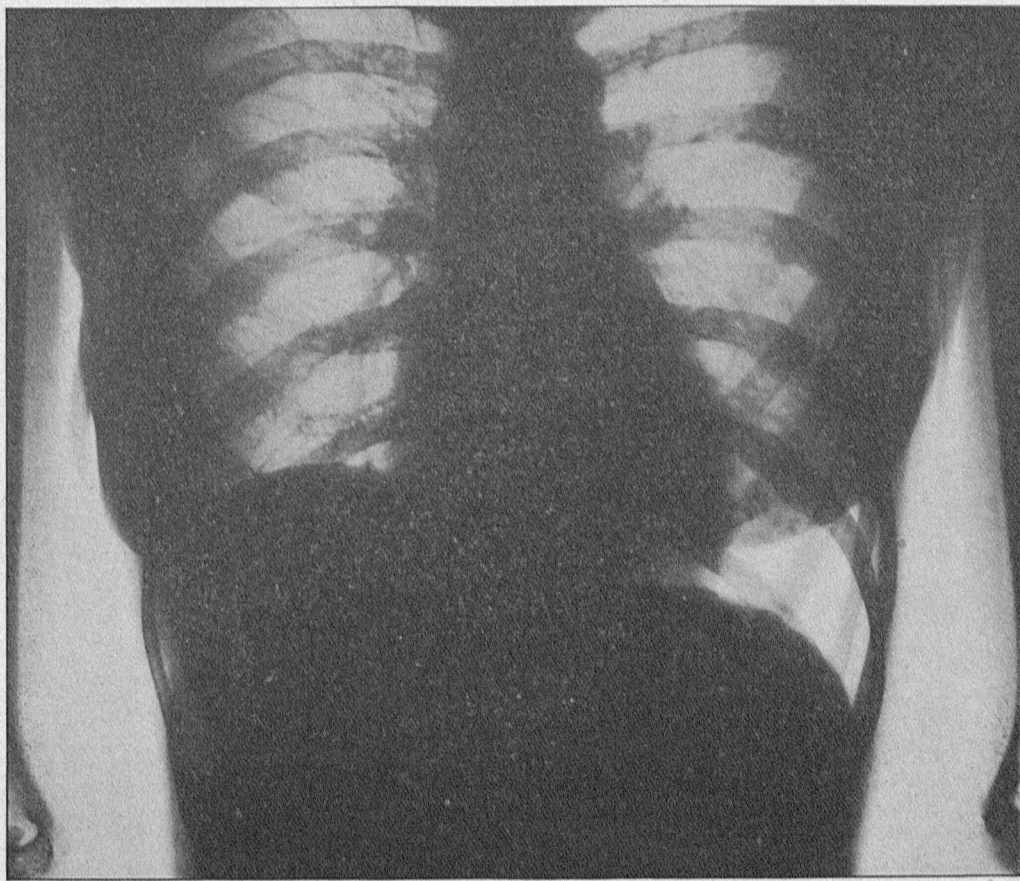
X-ray in sitting position of CASE 3, 3½ months after operation. Wounds now entirely healed and patient feels perfectly well. Note that right diaphragm still remains high. By fluoroscope the excursion of right diaphragm is still very limited. (X-ray by Dr. Frank Wheatley).
